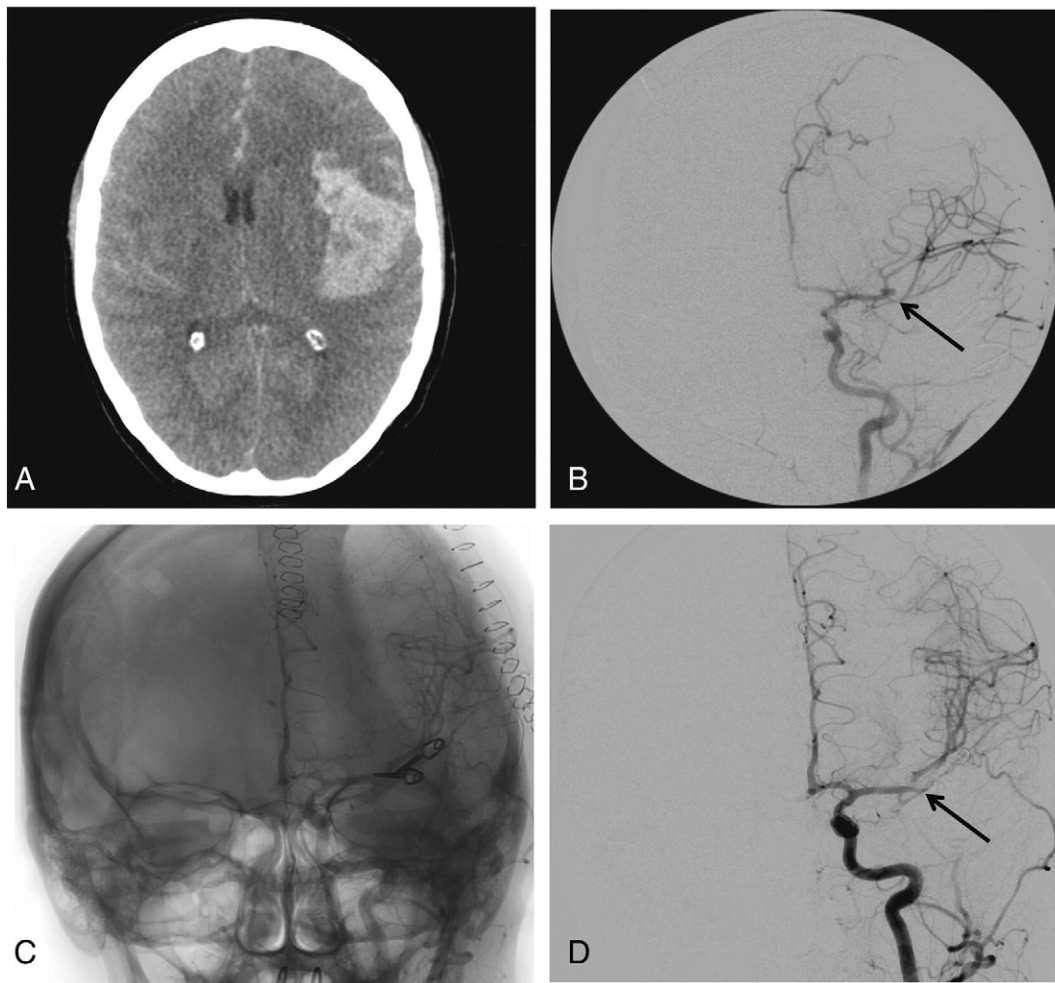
Imaging studies for case 1. (A) The initial computed tomography (CT) scan showing a left temporal intracerebral hemorrhage (ICH) in coronal view, diffuse subarachnoid hemorrhage (SAH), and intraventricular hemorrhage (IVH). (B) The intraoperative diagnostic C-arm angiography demonstrating a bilobed aneurysm at the left middle cerebral artery (MCA) bifurcation, as indicated by the arrow in left anteroposterior view. (C) The post-operative digital subtraction angiography (DSA) (obtained with biplanar angiography 1 day postoperatively) showing the two aneurysm clips in anteroposterior view. (D) The subtracted view of post-operative catheter angiography (1 day postoperative) demonstrating no filling of the aneurysm, as indicated by the arrow in anteroposterior view.
